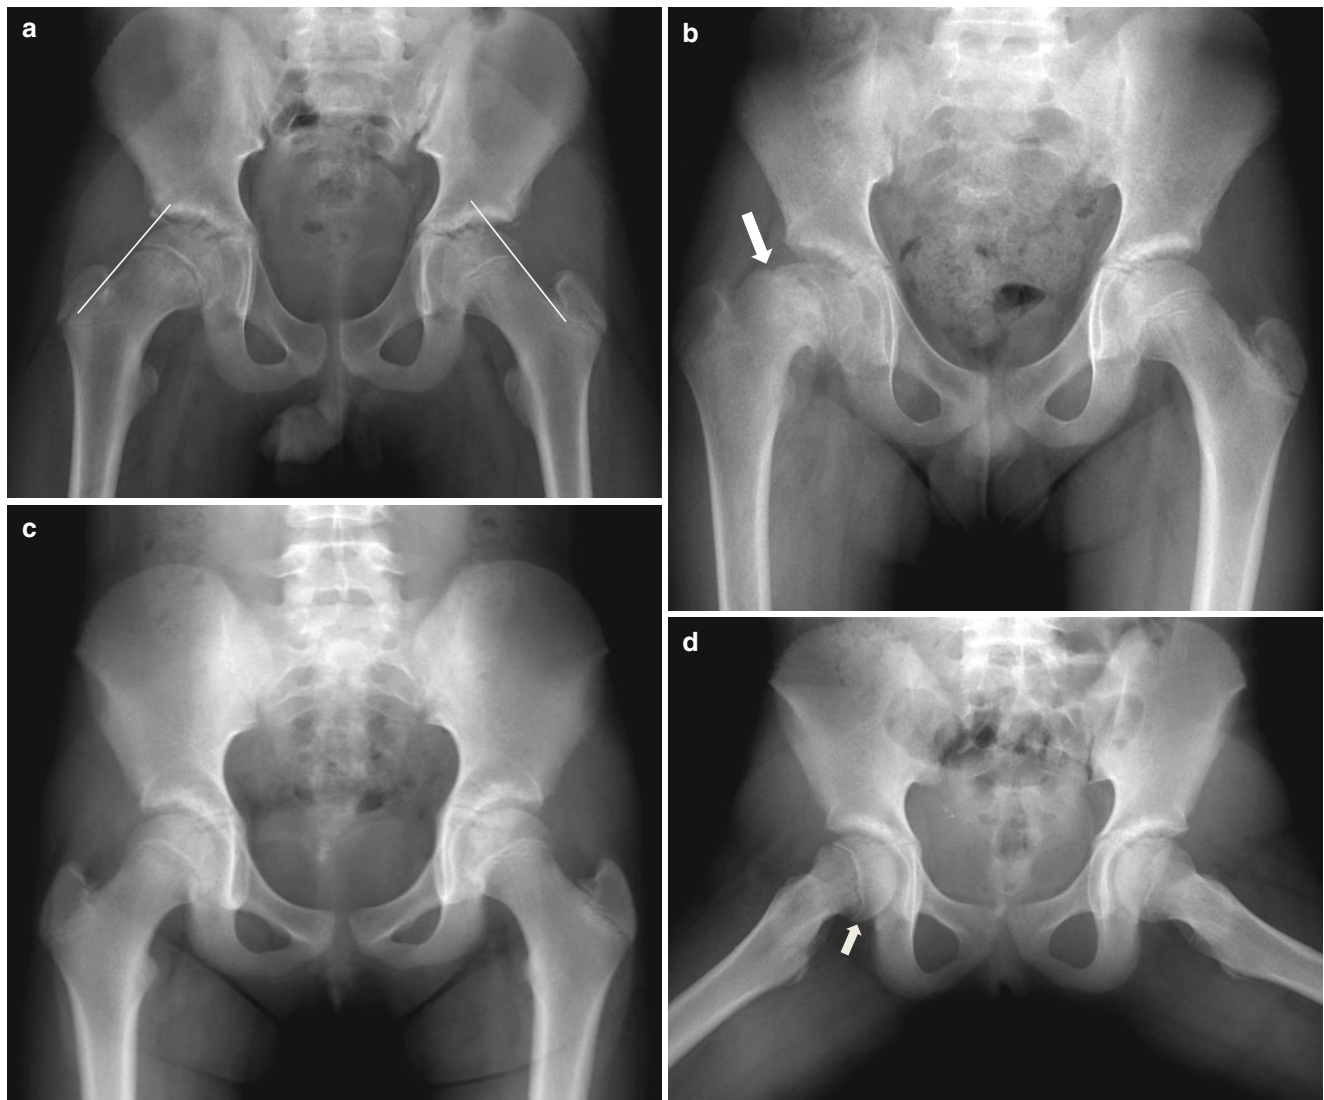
Radiographic appearance of slipped capital femoral epiphysis. (a) Appearance of acute SCFE. Anteroposterior radiograph in an 11-year-old boy with acute-onset right hip pain shows an abnormally widened proximal femoral growth plate. Klein line, a line drawn along the lateral border of the femoral neck, would not intersect the femoral head. Normally, a small portion of the left femoral head should be lying lateral to the Klein line. (b) Anteroposterior radiograph in a 12-year-old boy with many months of right thigh discomfort shows slipped femoral
